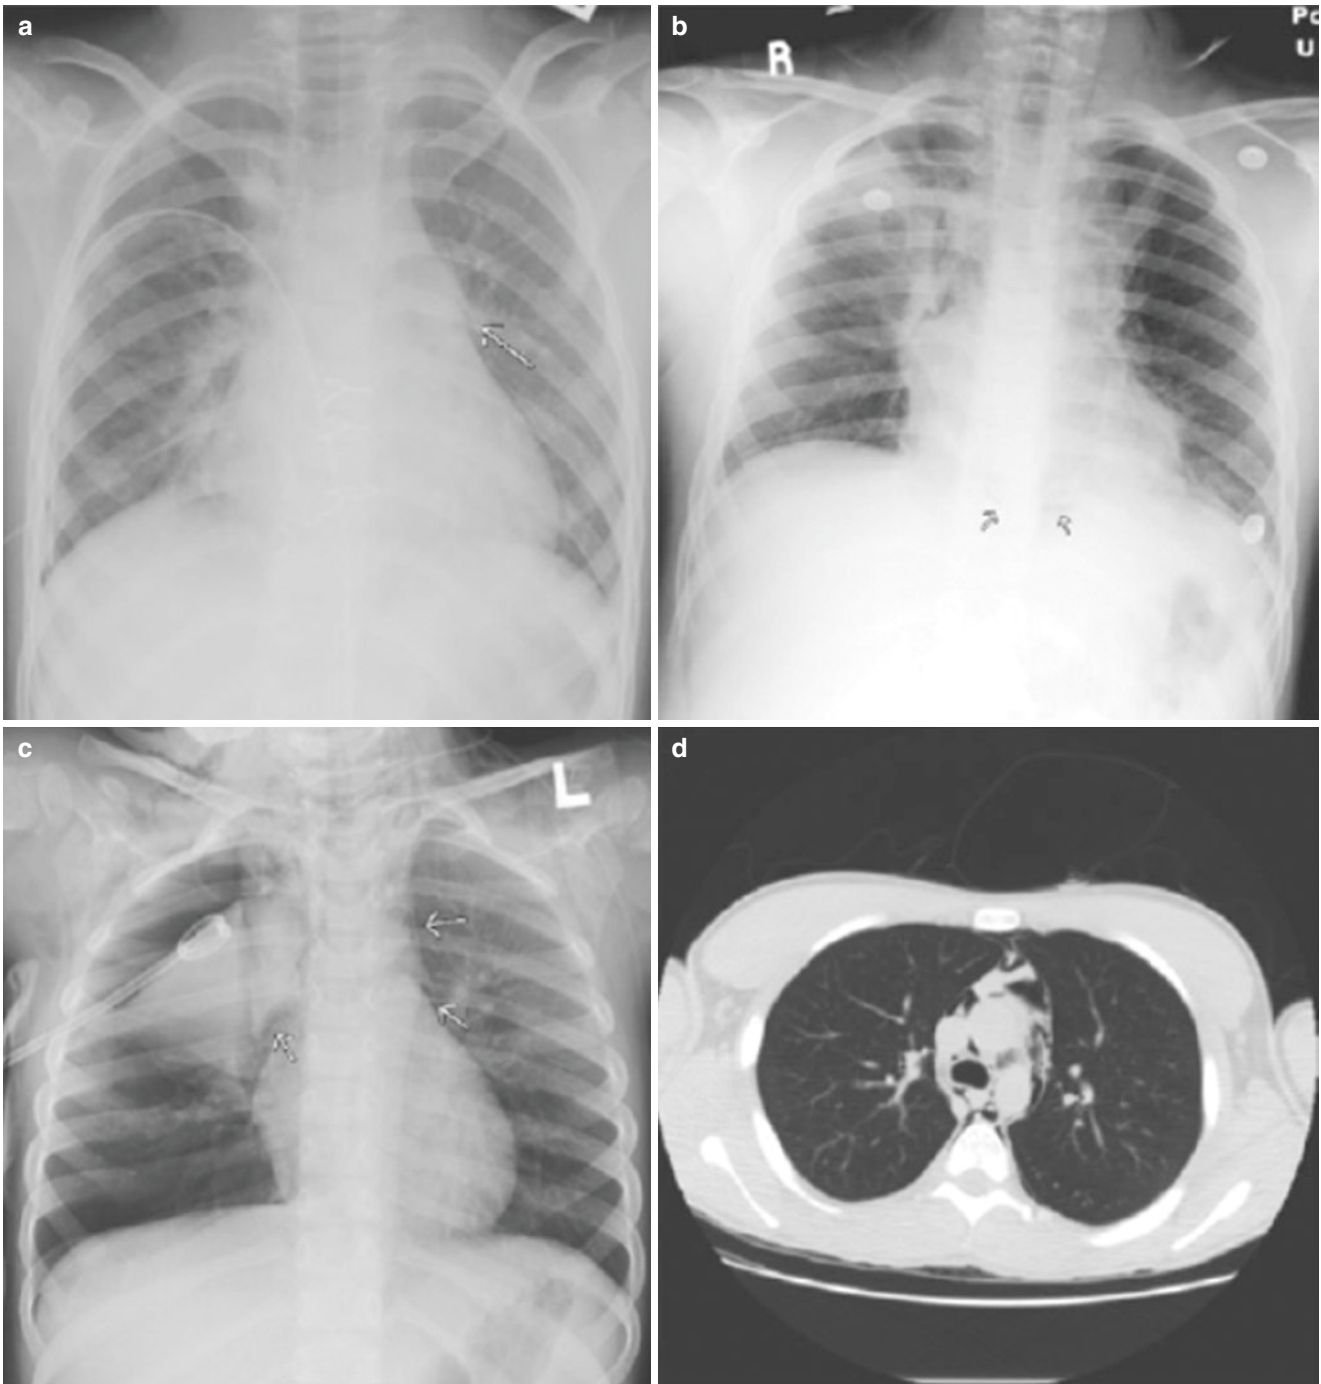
(a) There is a pneumomediastinum seen only on the left. It is distinguished from a medial pneumothorax by the small amount of air lifting the left lobe of the thymus off the mediastinum (*arrow*). (b) In a different patient, there is a relatively large pneumomediastinum, with a larger right component. A small amount of air is noted beneath the heart (*arrows*). Air also has extended into the neck. A small right pneumothorax is present. (c) Portable AP chest radiograph shows air
